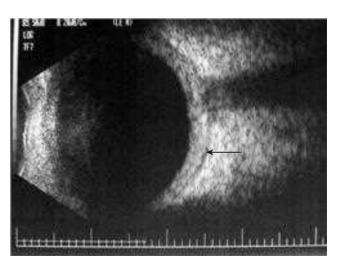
B-scan ultrasonography in posterior scleritis showing scleral thickening and fluid in the sub-Tenon space (arrow), with the characteristic 'T' sign (see text)
